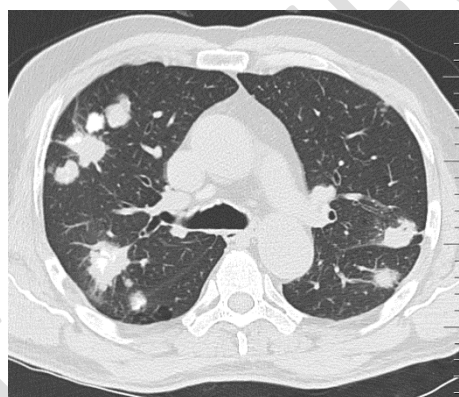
CT chest shows multiple calcified lung metastases
